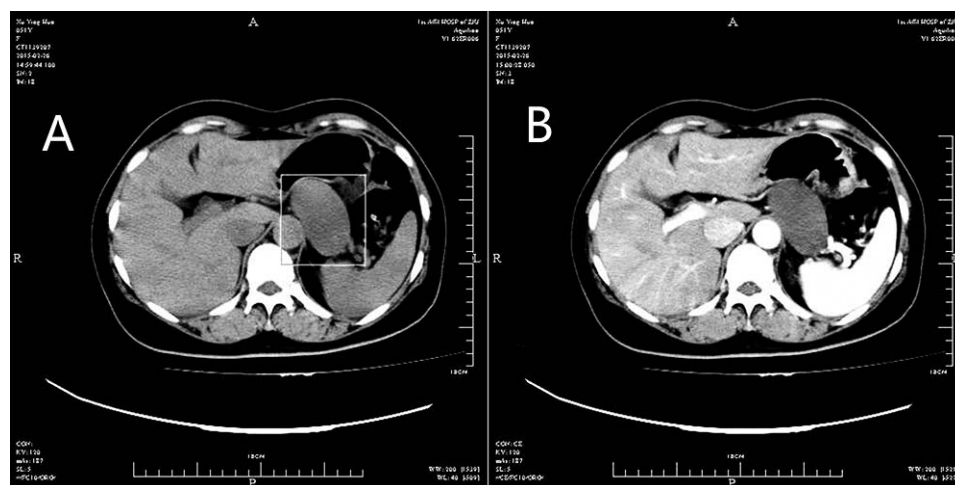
CT of this patient showed the cyst clearly. (a) Non-contrast enhanced CT revealed a thick-walled cyst (red box) posterior to the gastric wall. (b) The cyst did not show contrast enhancement in arterial phase of contrast enhanced CT.
